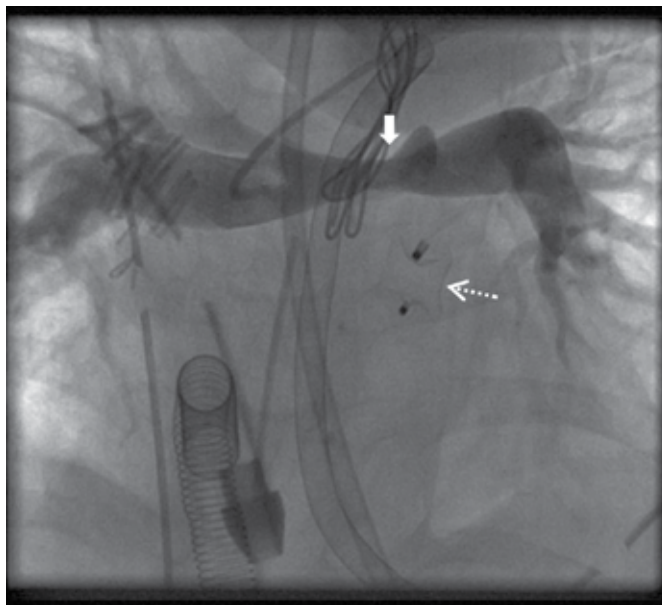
Clutter in the X-ray field. Legend—The image includes ECMO cannulas, chest drains, surgical clips, swabs, a nasogastric tube, a cardiac catheter and a vascular occlusion device (dashed arrow). There is a significant stenosis at the pulmonary artery bifurcation (solid arrow) following cardiac surgery (superior cavopulmonary shunt).
